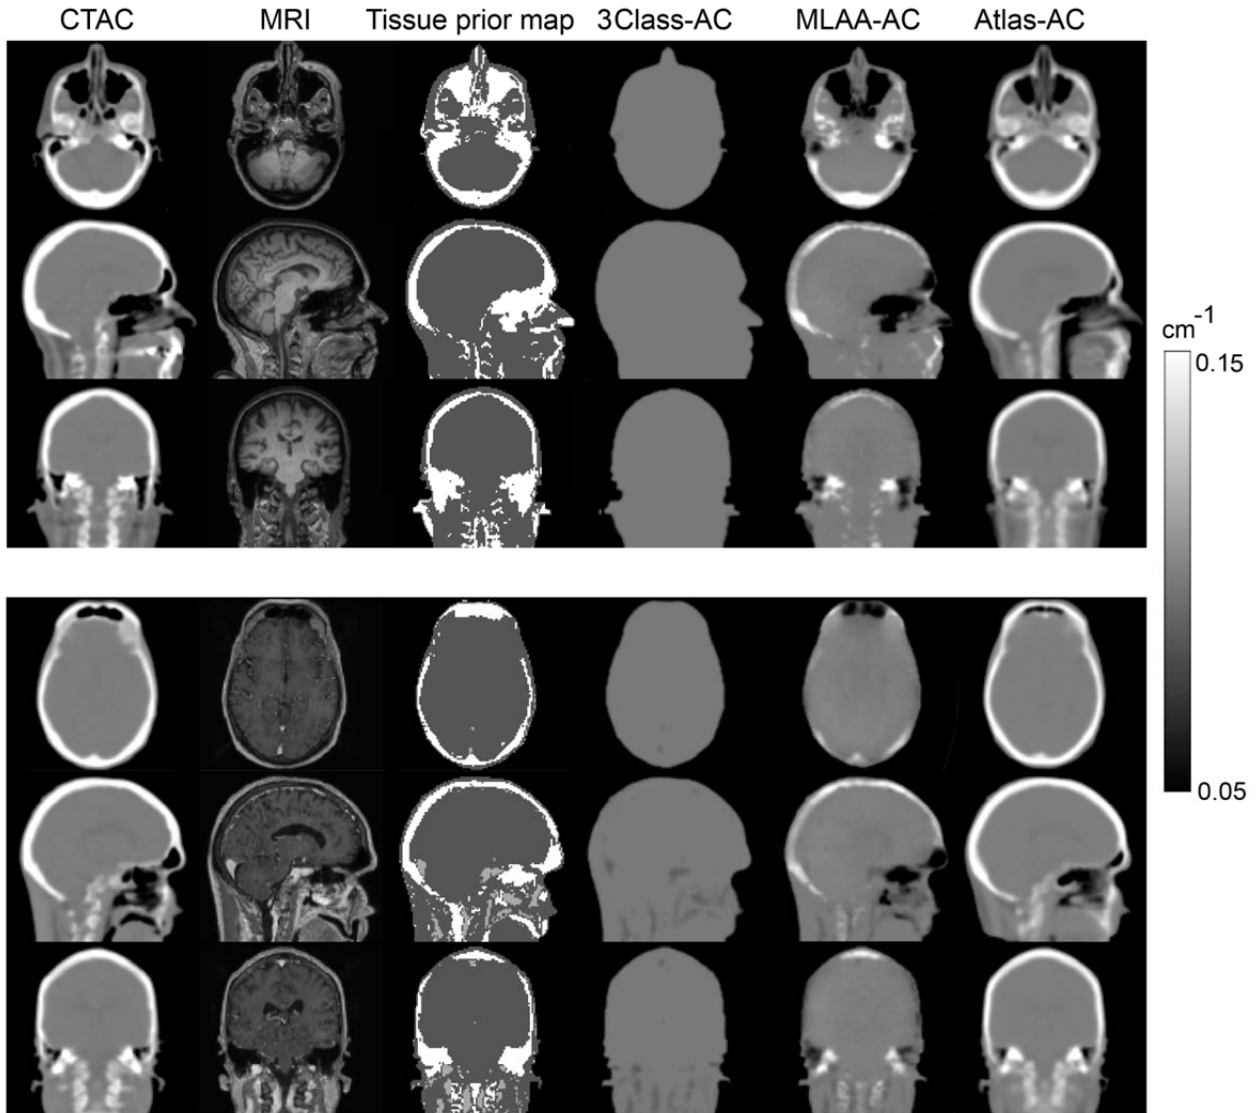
Comparison of the attenuation maps for two representative patients generated by the different attenuation correction techniques together with the reference CTAC map, the target MRI image and MR-based tissue prior map used for the MLAA algorithm.
